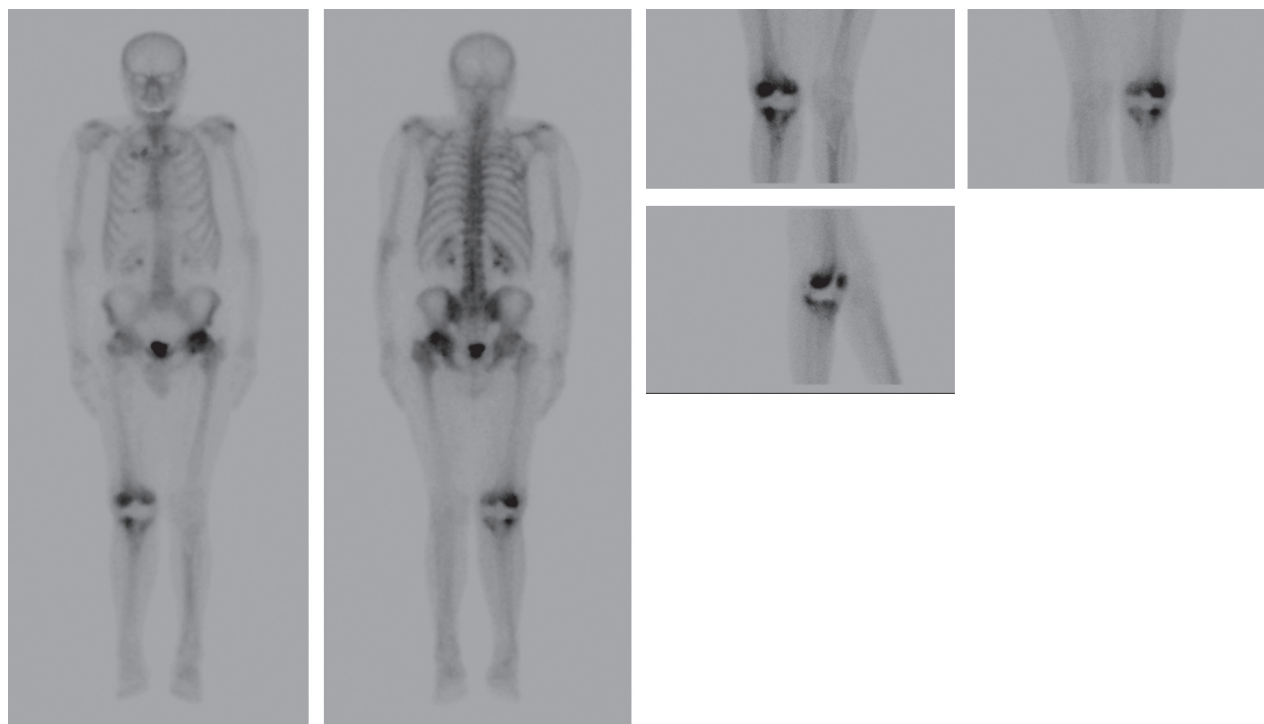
Bone scintigraphy shows high uptake at the righth knee TKA
